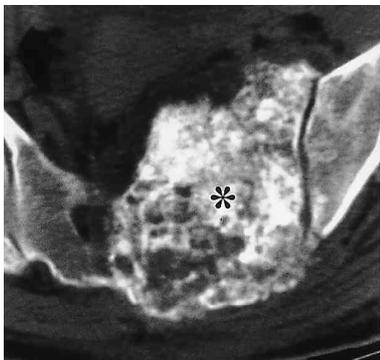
A. Helical CT scan of the pelvis shows dense calcified mass (starlet) in the sacrum confirmed as chondrosarcoma. B. CT scan of the pancreas obtained one month later shows multiple nodular masses with dense calcification in entire pancreas. C. Eighteen months later, CT shows increase size and number of the metastatic masses through the pancreas.
